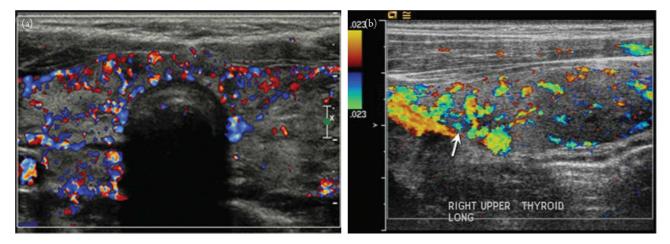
(a) This transverse image of the thyroid gland (arrow) shows diffuse enlargement and hypervascularity in this patient with Hashimoto thyroiditis. From Figure 133.3 of Scoutt LM, Hamper UM, Angtuaco L, eds. *Ultrasound*. Oxford, UK: Oxford University Press; 2017. (b) Longitudinal image of the right thyroid gland (arrow). This image shows a "thyroid inferno" pattern of hypervascularity on color Doppler in a patient with Grave's disease. From Figure 2C of McIver B, Fatourechi MM, Hay ID, Fatourechi V. Grave's disease after unilateral Riedel's thyroiditis. *J Clin Endocrinol Metab*. 2010; 95(6):2525–2526.
